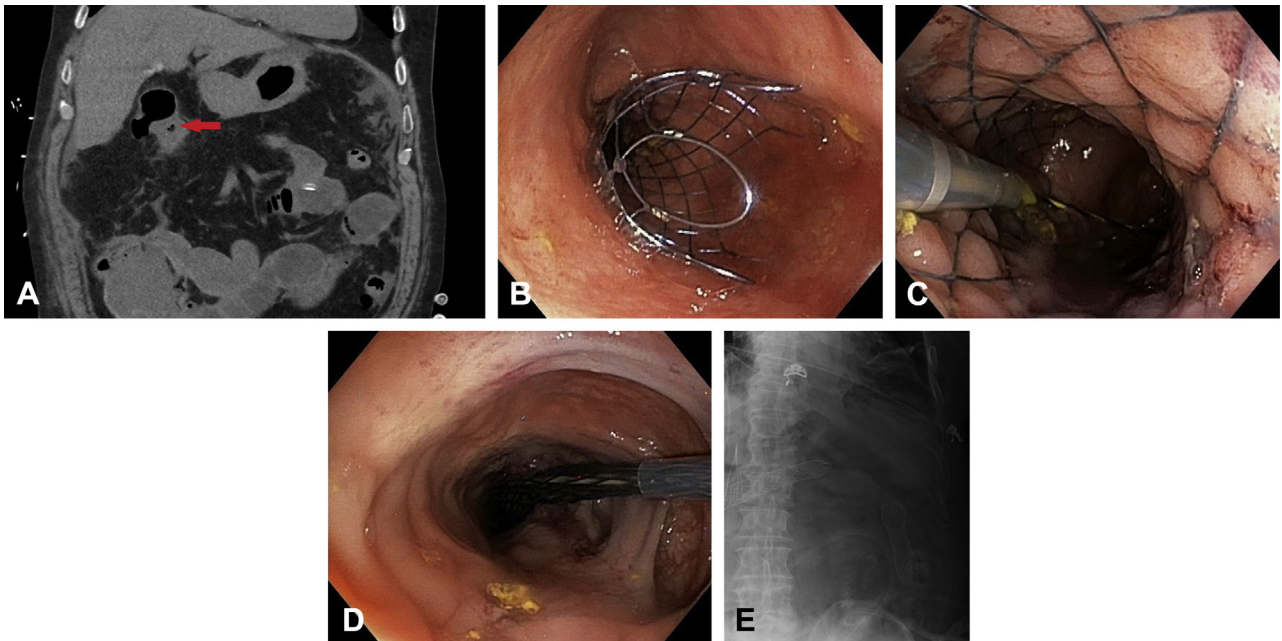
A, CT coronal view of abdomen and pelvis without contrast medium showing transition point (*arrow*) at the hepatic flexure concerning for large-bowel obstruction. B, Endoscopic view of descending colon stent placement. C, Endoscopic view of colonic stent catheter and ultra-slim colonoscope across the descending colon stent. D, Endoscopic view of stent deployment across hepatic flexure stricture. E, Abdominal radiographic view of the hepatic flexure and descending colon stents after the procedure.
